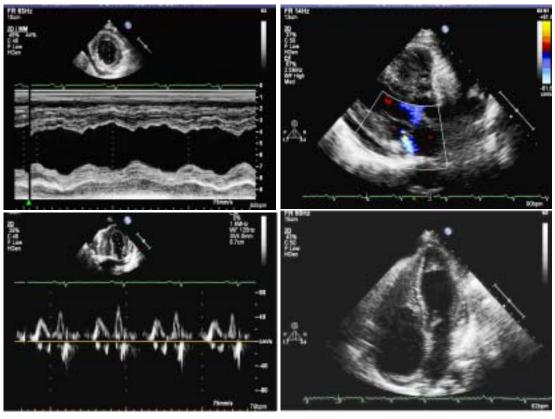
Echocardiogram showing biventricular hypertrophy with obliteration of the apex, mitral regurgitation, diastolic dysfunction and a pericardial effusion.
